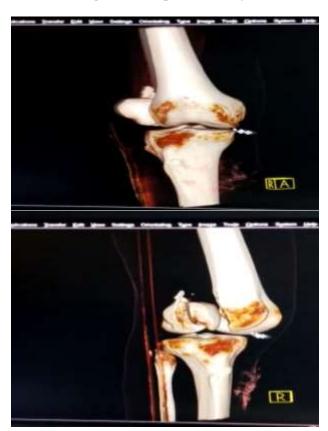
Preoperative 3D CT imaging.
